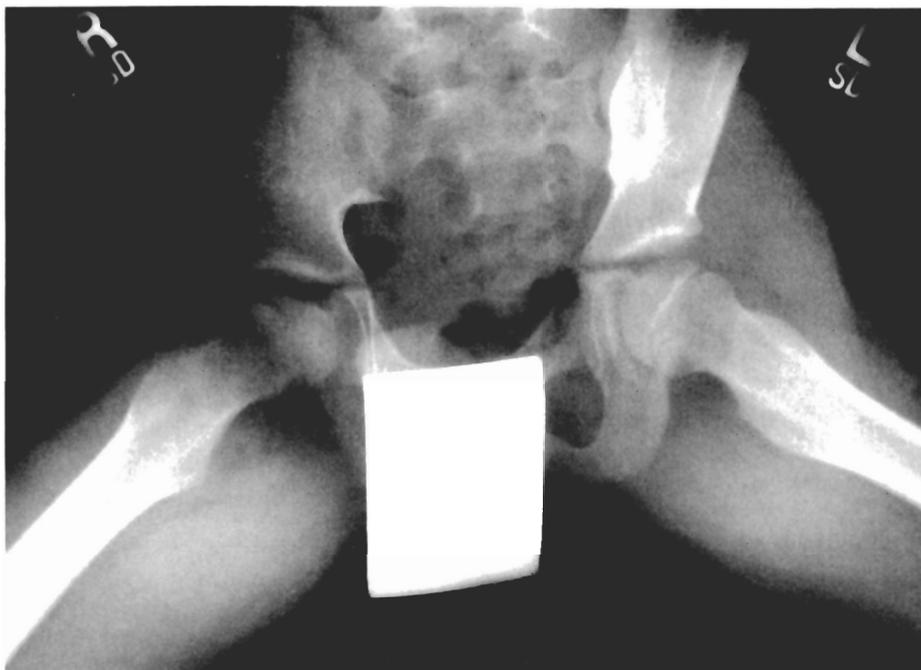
An X-ray of the pelvis demonstrating irregularity of the right hip, which is indicative of Perthes disease. Note widened epiphyseal plate and flattened femoral head.
